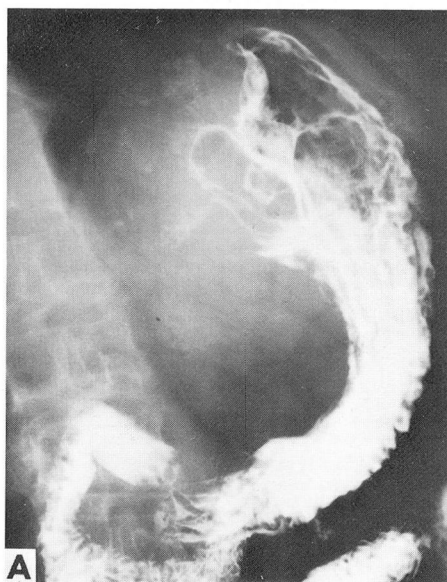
A, Roentgenogram, after conventional barium swallow, showing an abnormal gastric fundus. B and C, Barium spray of the gastric fundus has outlined an air-contrast view of a large exophytic gastric neoplasm (arrows) that was found to be an adenocarcinoma at operation.
